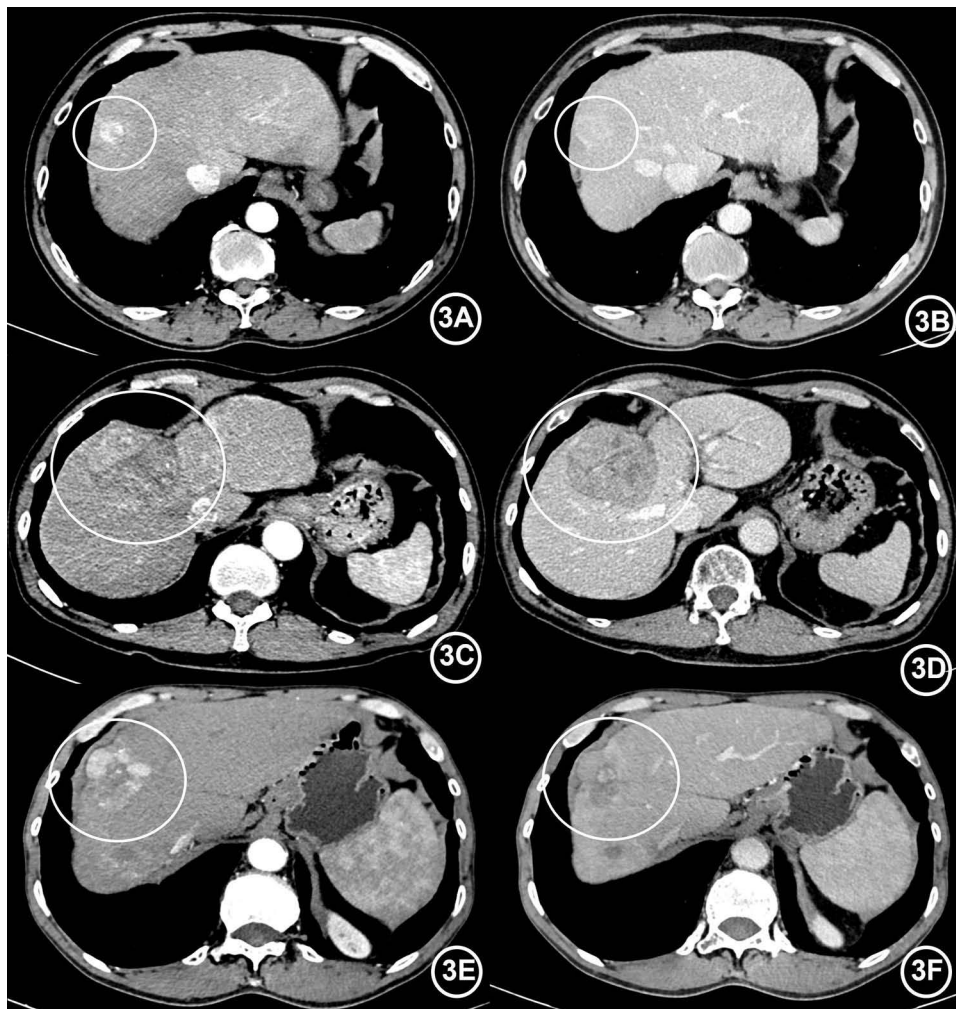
Differentiation-related imaging. (3A and 3B) A 70-year-old man with HCC, well differentiated. AP (3A) and PVP (3B) images show smooth tumor margin, tumor capsule, peritumoral enhancement, and typical enhancement pattern. The maximum tumor length is 33mm. The CT value in AP and PVP are 97Hu and 85Hu respectively. (3C and 3D) A 75-year-old man with HCC, moderately differentiated. AP (3C) and PVP (3D) images show smooth tumor margin, intratumoral artery, tumor capsule, cystic degeneration or necrosis, and typical enhancement pattern. The maximum tumor length is 64mm. The CT value in AP and PVP are 77Hu and 83Hu respectively. (3E and 3F) A 58-year-old man with HCC, poorly differentiated. AP (3E) and PVP (3F) images show irregular tumor margin, intratumoral artery, peritumoral enhancement, cystic degeneration or necrosis, and typical enhancement pattern. The maximum tumor length is 41mm. The CT value in AP and PVP are 101Hu and 79Hu respectively.
